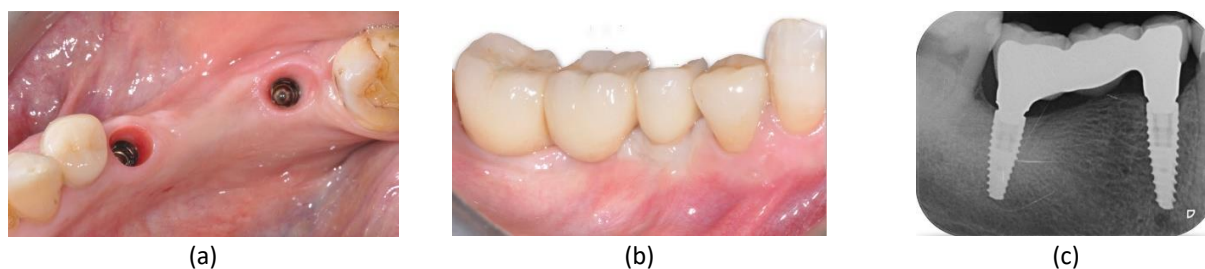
Patient 1: (a) Healing at 3 months post-op; (b) placement of standard metal ceramic bridge; (c) X-ray control.
